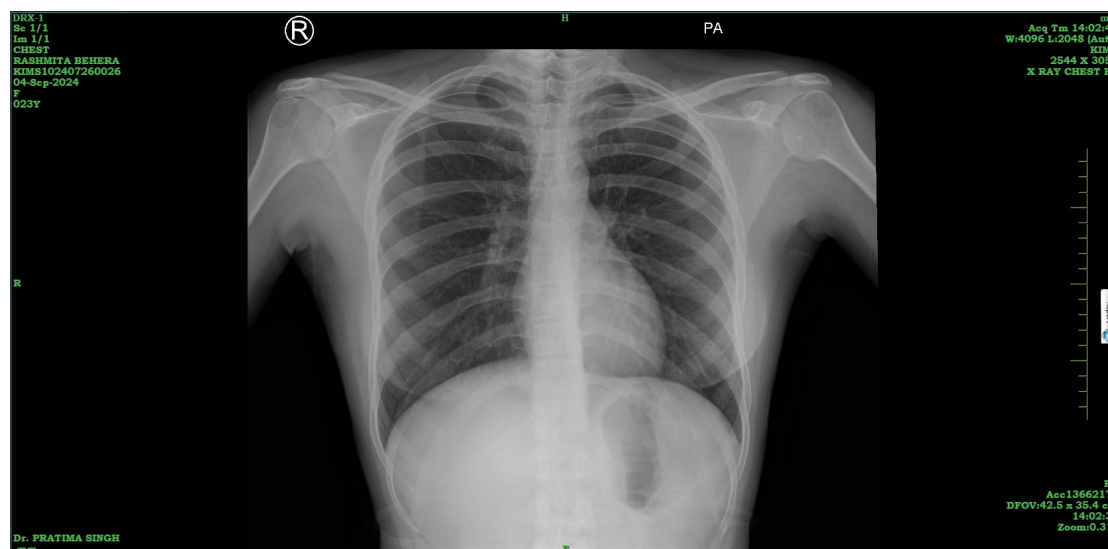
Chest radiograph showed no abnormal findings.
